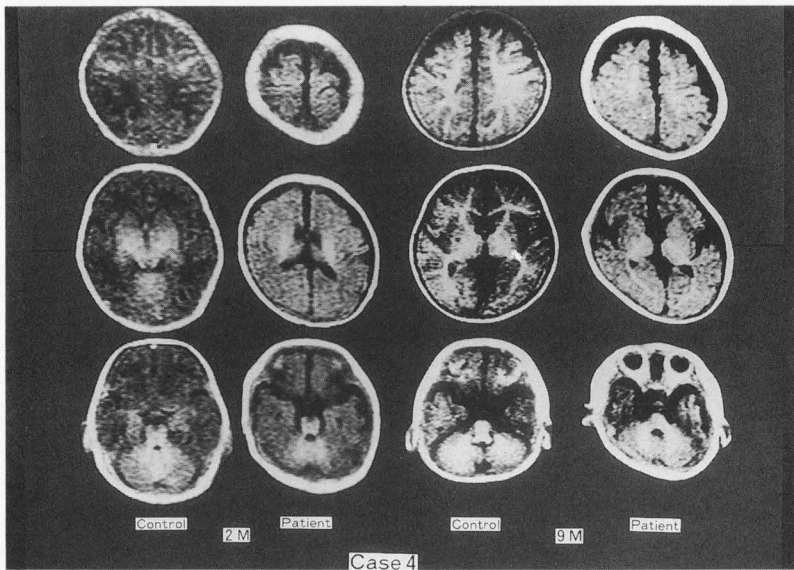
MRI on IR (2100/500) scans in case 4 disclosed no abnormal findings at two months old (Left), and a delay in the myelination of white matter at nine months old compared with in an age-matched control (Right).
